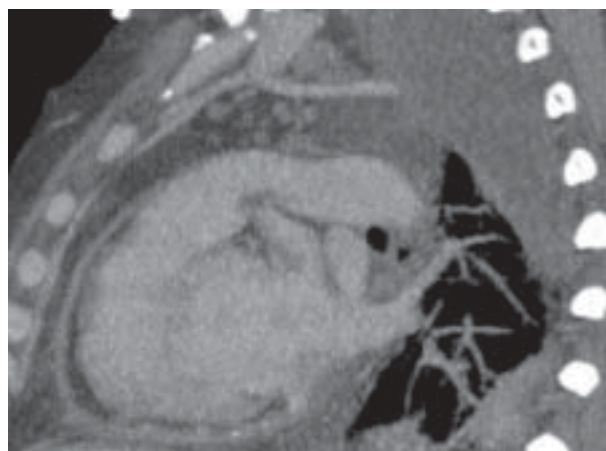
Computed tomography. Substantial thickening of the pericardium
